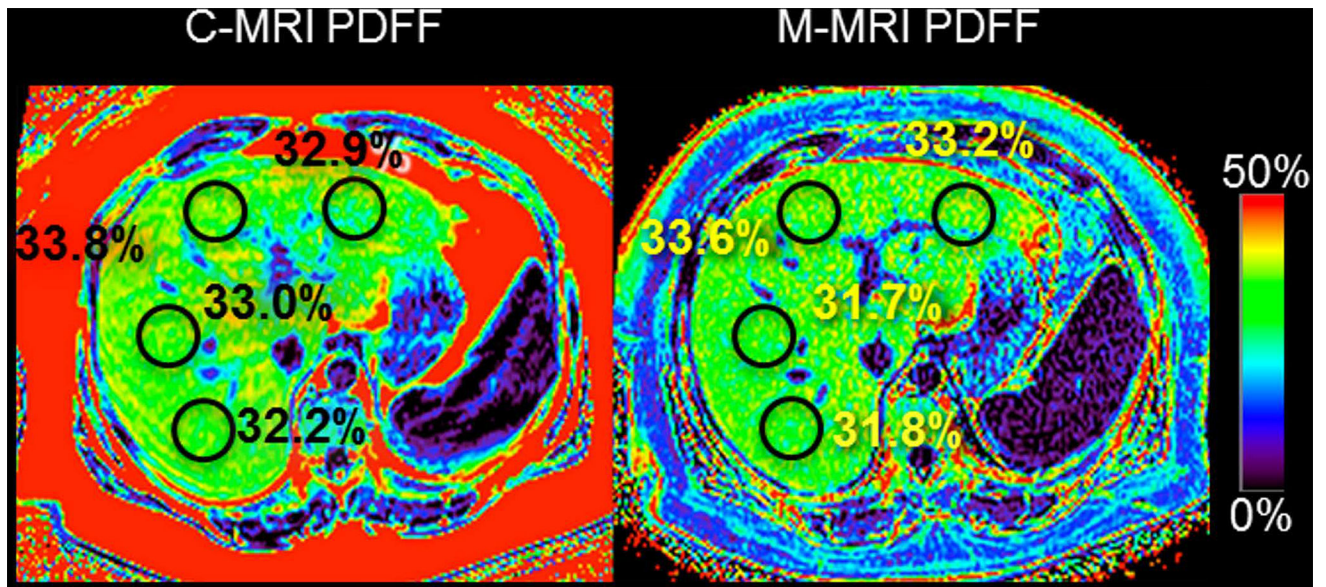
MRI-PDFP assessment and quantification of hepatic steatosis
